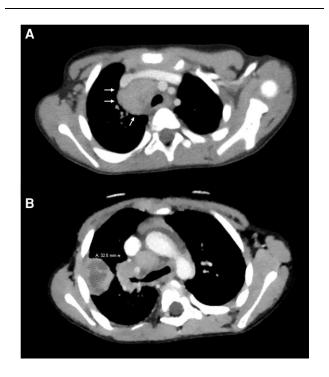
Cross-sectional computed tomographic imaging of the chest with arrows indicating the presence of a right paratracheal lung mass (A) and hilar adenopathy with a large necrotic right pulmonary mass measuring 32.55 mm in diameter (B).
